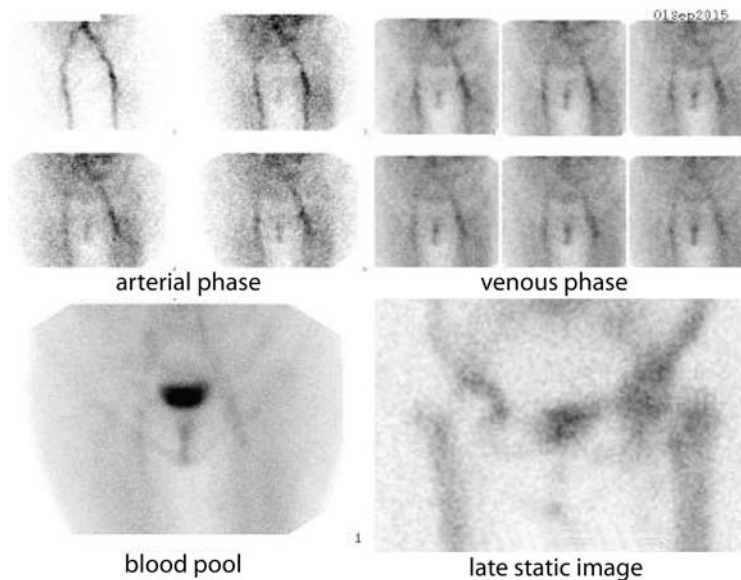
The results of three-phase ^{99m} technetium methylene diphosphonate (^{99m}Tc-MDP) bone scintigraphy are negative at all stages of the imaging. Definite result: inadequate joint biomechanics due to adductor muscle weakness – aseptic.
